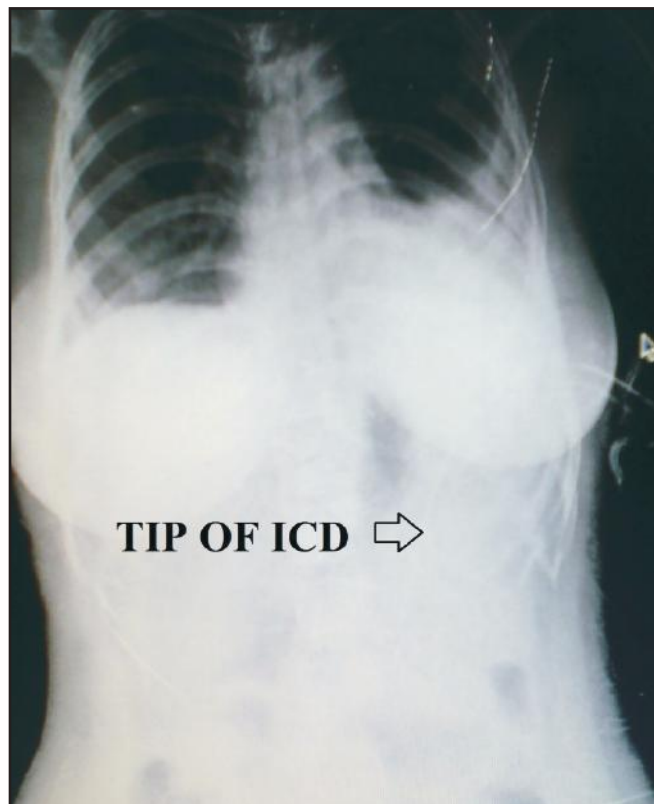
Chest X-Ray on presentation showing left sided pleural effusion and tip of ICD in the abdomen
